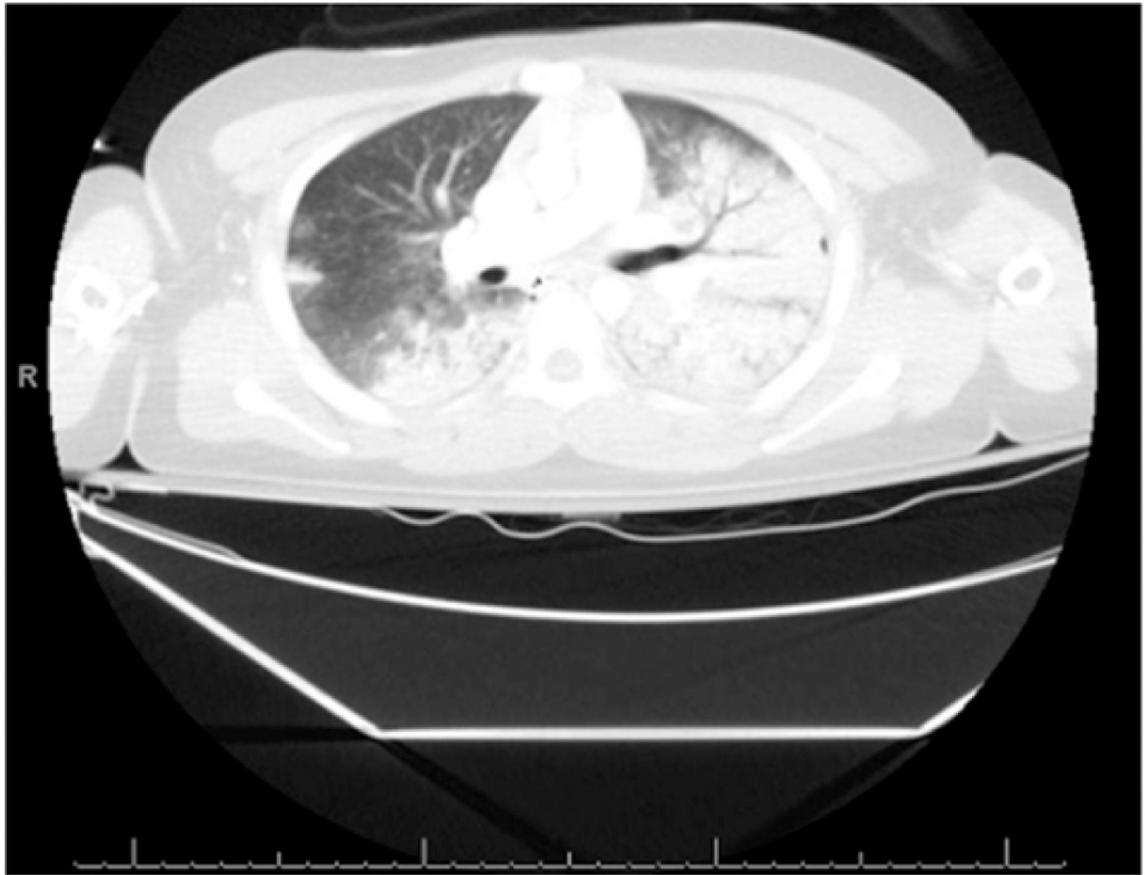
Initial chest computed tomography from day of injury showing massive left pulmonary contusion and pneumonitis.
